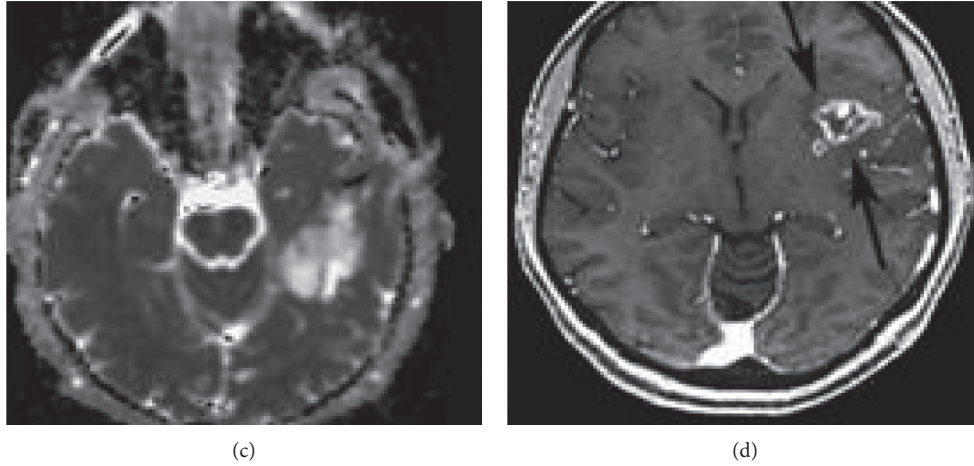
An MRI image of a female with BG. Low-grade astrocytoma of the left temporal lobe showed uneven enhancement for T1WI (a), low signal for DWI (b), and high signal for ADC (c). The glioblastoma on the left insular lobe showed uneven enhancement for T1WI (d).
